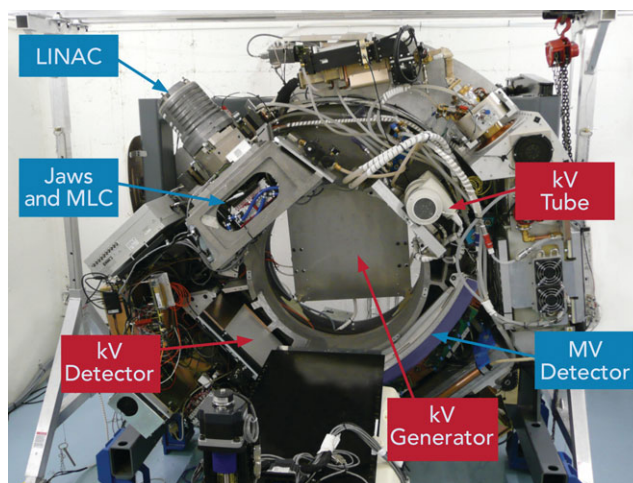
A picture of the experimental tomotherapy system, highlighting the kV x-ray tube and detector mounted orthogonal to the MV beamline. The kV generator is mounted to a metal plate on the back side of the gantry. [Color figure can be viewed at [wileyonlinelibrary.com](http://wileyonlinelibrary.com)]
